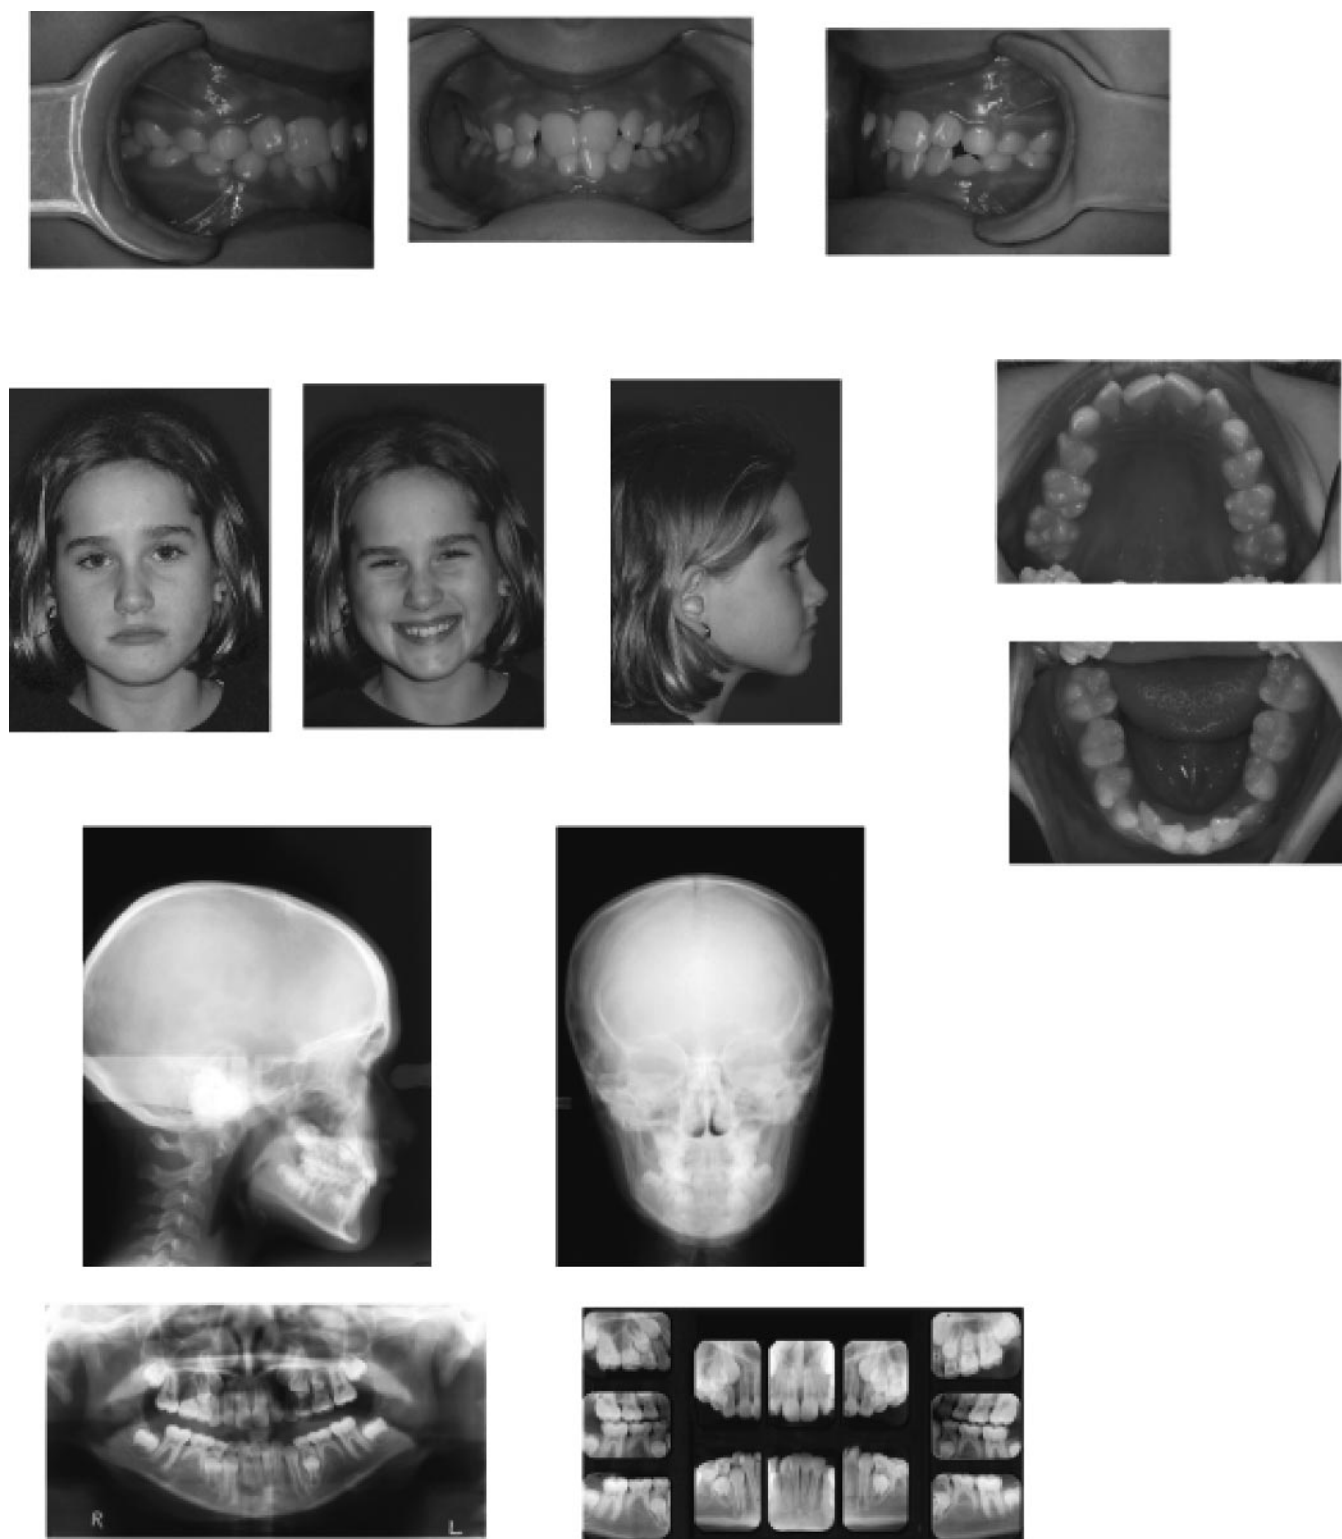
Pretreatment panoramic radiograph, lateral cephalometric radiograph, posterior-anterior cephalometric radiograph, full mouth series, pretreatment facial photographs, and intraoral photographs.
